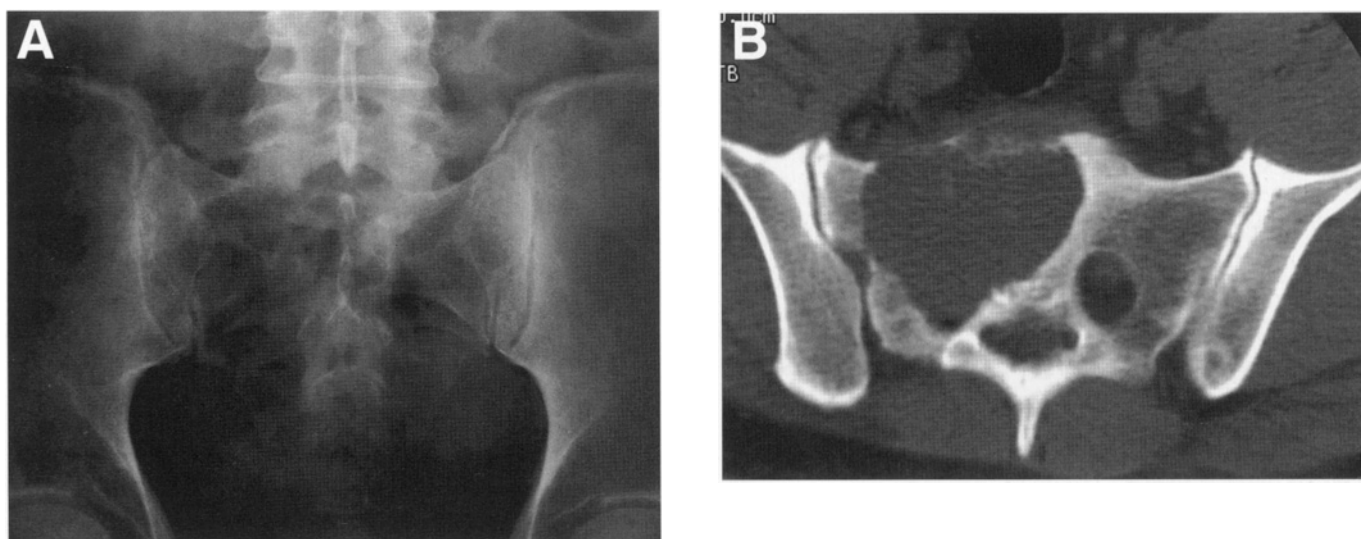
A 55-year-old male with a low back and posterior thigh pain. (A) Anteroposterior plain radiograph of the pelvis was read as normal. (B) CT of the pelvis revealed a large destructive lesion of the sacrum. CT of the abdomen revealed a renal mass, and a CT-guided core needle biopsy of the sacral lesion confirmed the diagnosis of metastatic hypernephroma. Complete staging revealed additional asymptomatic vertebral metastases. The patient was treated with embolization of the sacral lesion with complete resolution of his pain.
